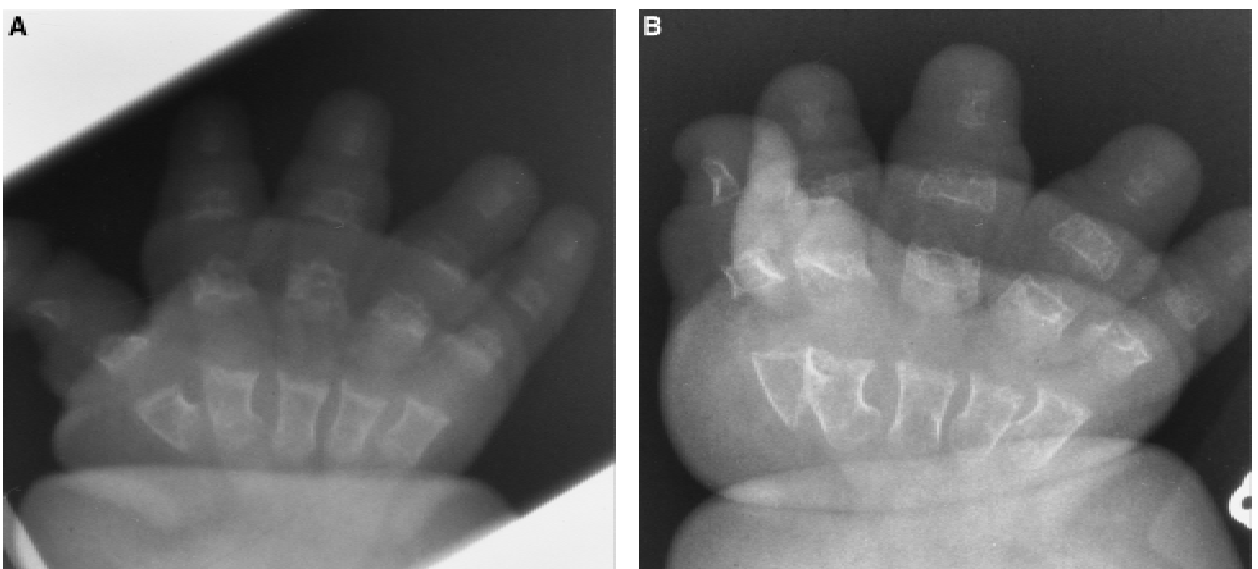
Hand radiographs at 6 months (A) and 3.3 years (B).
